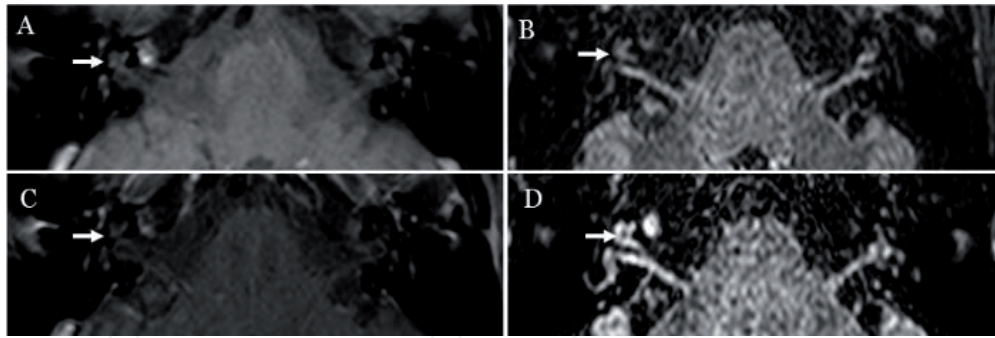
Vascular pattern of SSSL. Pre-contrast T1w (A) and 3D-FLAIR (B) sequences show a high signal in the right cochlea (arrow), without enhancement on postcontrast T1w (arrow, C). The inner ear enhancement on 3D-FLAIR sequence is consistent with blood-labyrinth barrier breakdown of the inner ear (arrow, D).
